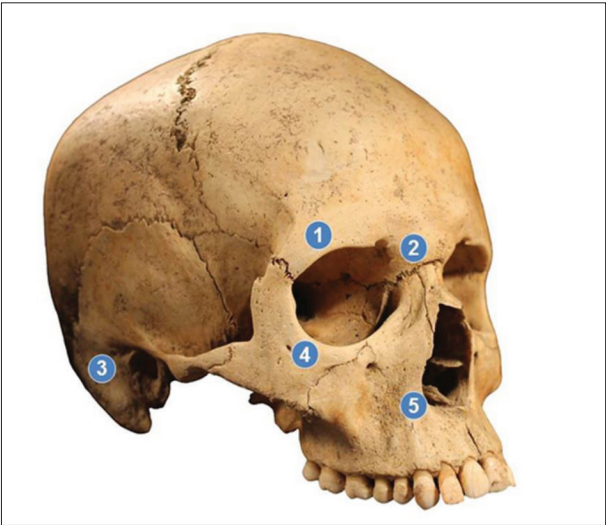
Micro-computed tomography scanning areas
